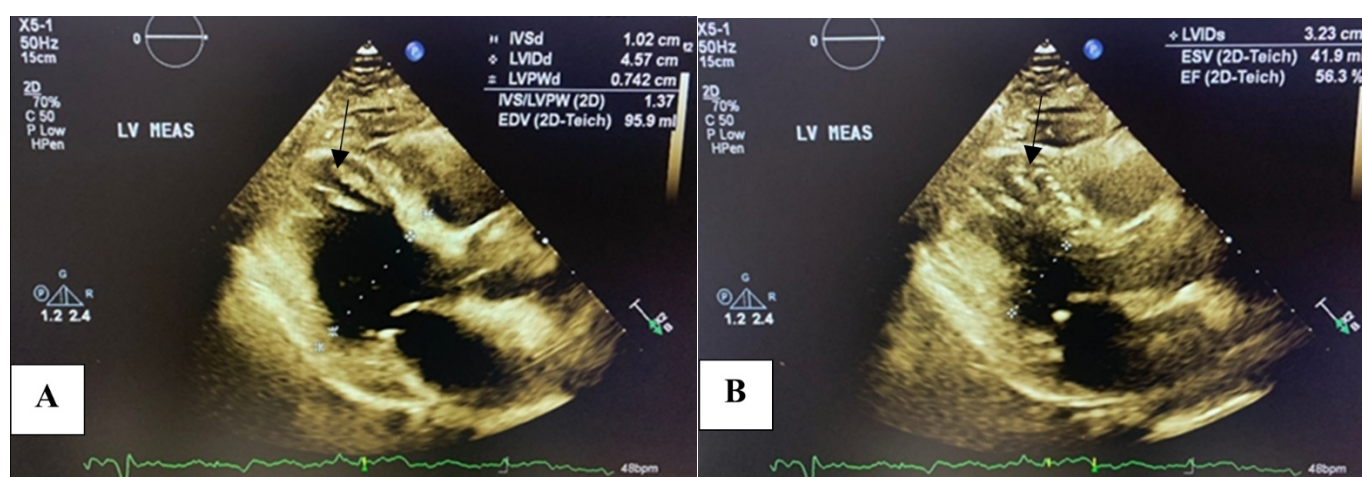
Transthoracic echocardiogram in apical four-chamber view on admission. (A) Diastolic phase and (B) systolic phase reveal apical ballooning of the left ventricle, with a visible apical thrombus (black arrow).
